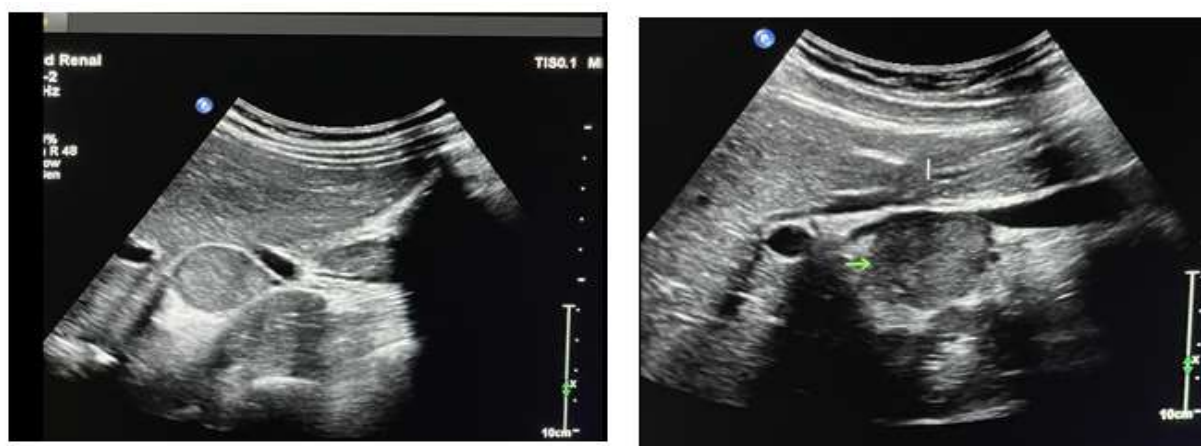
and Fig 1B. Sagittal and axial view: ultrasonography of right hypogastrium showing hypoechoic mass lesion. (green arrow)
